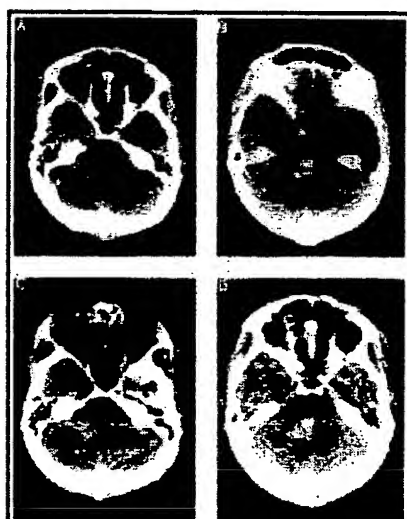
A, B, C, and D, computed tomographic scans of the brain with right cerebellar hemorrhage associated with irregular lucency in area of cerebellar hemisphere and brain stem.
